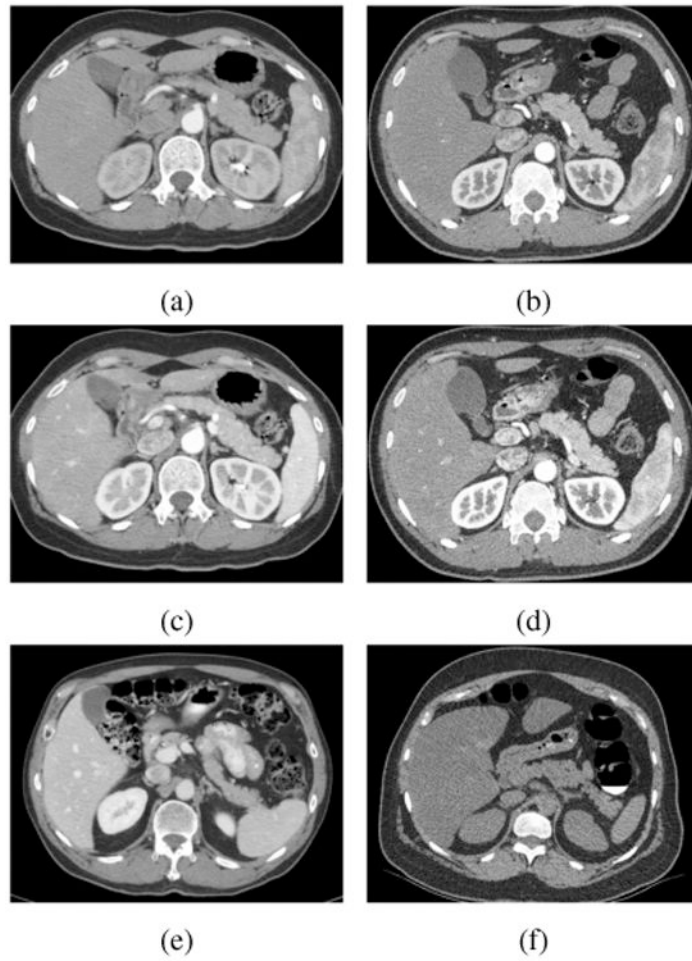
Examples of cross-sectional CT images of our data. See Table 4 for the descriptions of each IC. (a) A-1, (b) A-2, (c) B-1 (d) B-2, (e) C, and (f) D.
